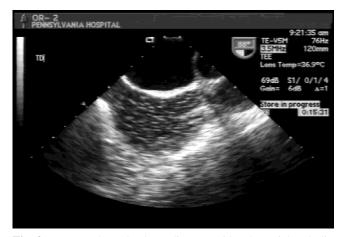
Transesophageal echocardiogram with substantial embolic activity after tourniquet release in a non-suction case example.
